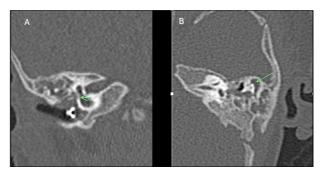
(A) Coronal CT of the temporal bone shows a stenotic bivalve window with a hypoplastic stapes footplate. (B) Axial CT of the temporal bone shows dysmorphic ossicular chains.
